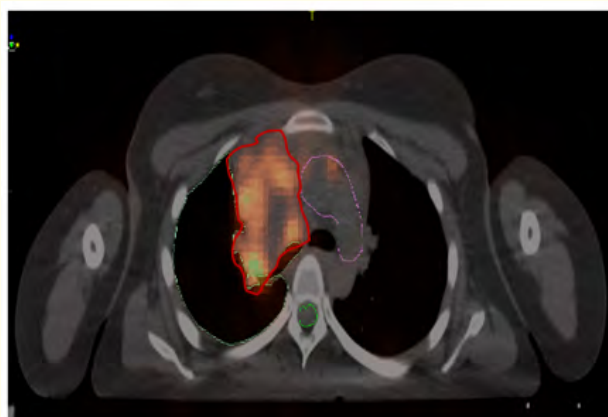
Volume delineation in PET-CT/ TA images.
